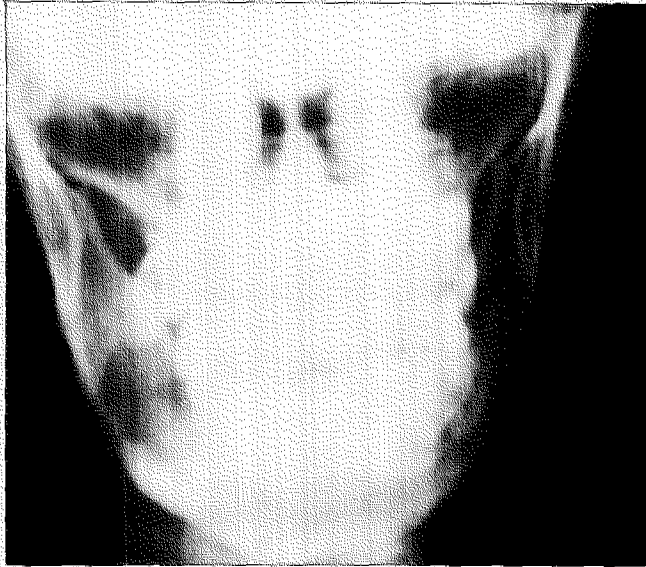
Mandibular x-ray series showed a focus of expansile-lytic destruction in the right mandible which appeared to have displaced one of the molars.
